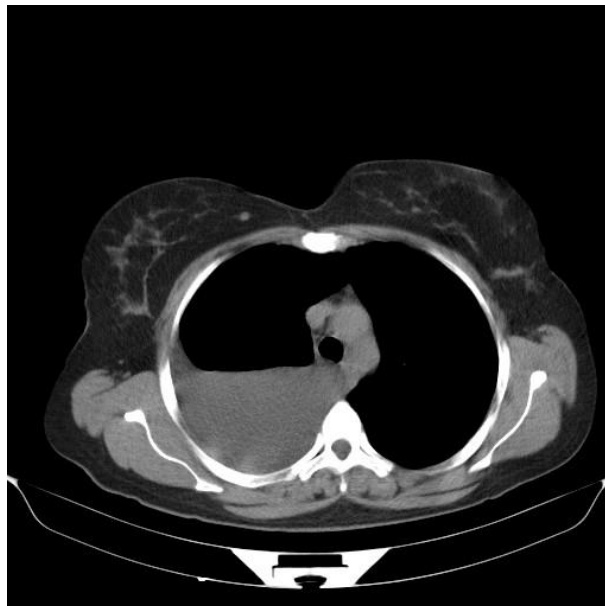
Contrast enhanced CT with intraperitoneal infused contrast-mixed dialysate
